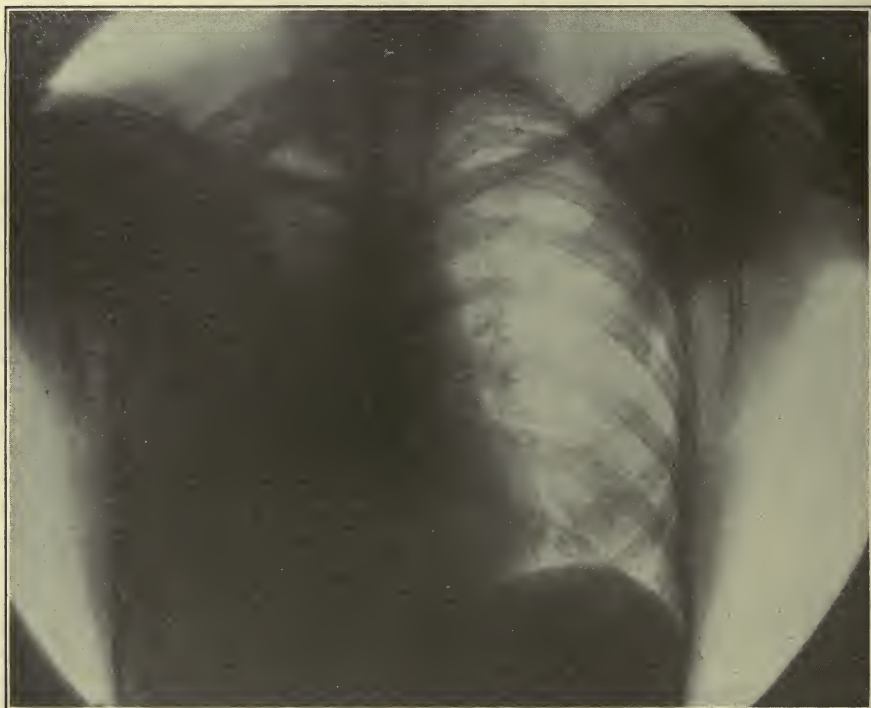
X-ray Picture of Pleural Effusion.
